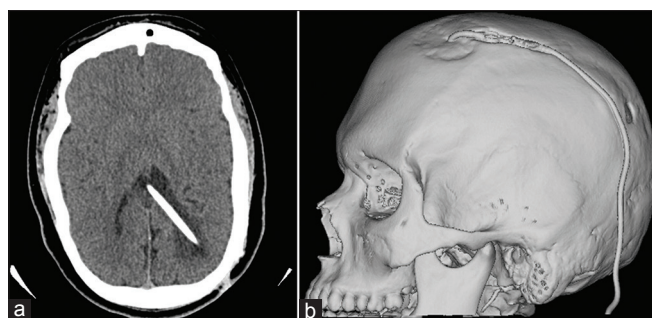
(a) Axial image of computed tomography scan of brain without contrast with dysmorphic lateral ventricles are noted with a shunt catheter in place in patient A. (b) Three-dimensional rendering from computed tomography images of the head of the cerebral shunt in patient A
